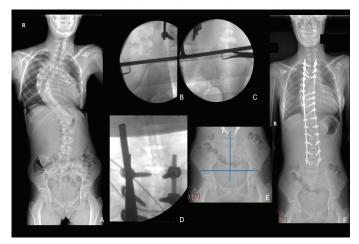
A 16-years old patient was operated on for AIS. (A) Preoperative scoliosis X-ray of the patient. (B-E) The patient had a preoperative LLD, therefore the T-tool was placed on the superior borders of the iliac crests and the construct was fixed considering the LLD. To achieve an optimal coronal alignment, the vertical arm should intersect the midline of the spinous process. (F) Postoperative scoliosis X-ray showed that the coronal balance was achieved in the patient
